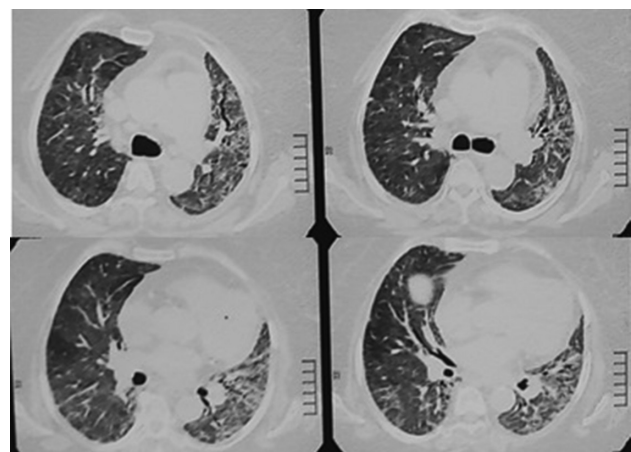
CT scan thorax from a patient with long-COVID showing persistent abnormalities in the form of reticulations and ground glass opacities. CT, computed tomography.
